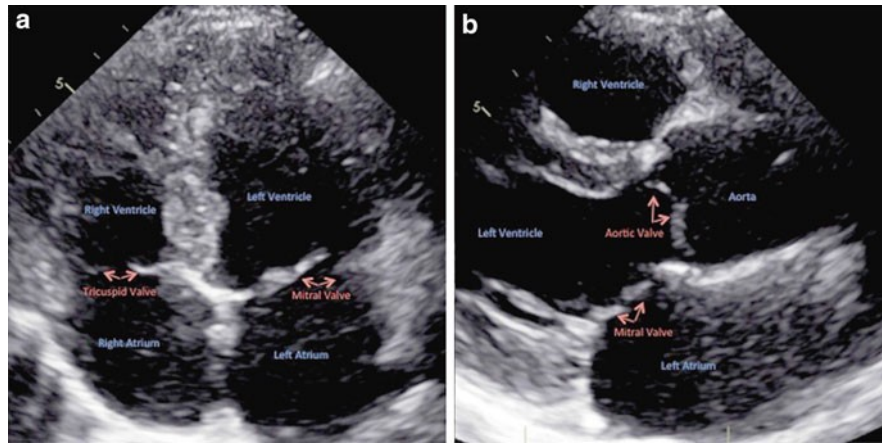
Normal transthoracic echocardiographic images. (a) Apical four-chamber image demonstrating the mitral valve separating the left atrium and left ventricle and the tricuspid valve separating the right atrium and right ventricle. (b) Parasternal long-axis image demonstrating the mitral valve separating the left atrium and left ventricle and the aortic valve separating the left ventricle and aorta
